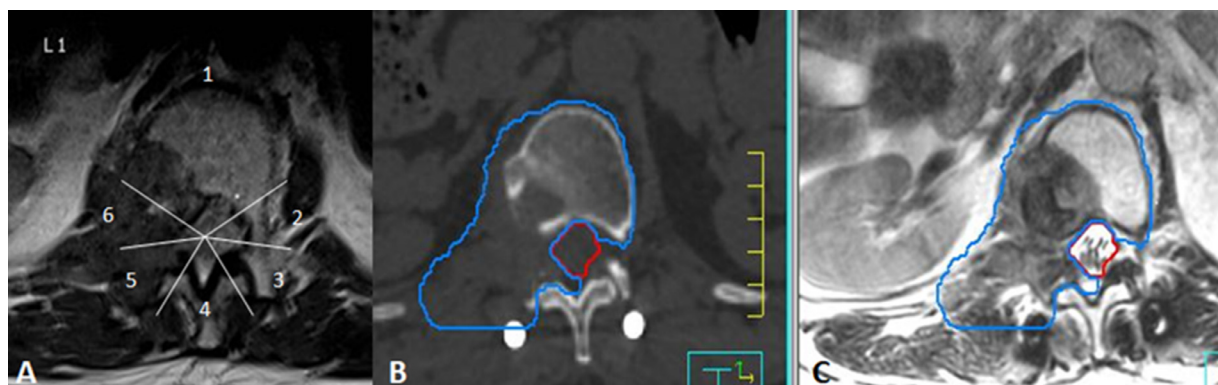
(A) Preoperative magnetic resonance imaging of a patient with an L1 metastasis centered around the right pedicle, transverse process, lamina and vertebral body. The International Spine Radiosurgery Consortium sectors have been superimposed on this image and reveal epidural disease involvement in sectors 1, 6, and 5. Postoperative computed tomography (B) and magnetic resonance imaging (C) show the clinical target volume applied to this target. Given the preoperative involvement, almost the entire epidural space is covered with sparing of the diametrically opposed International Spine Radiosurgery Consortium segment 3.
